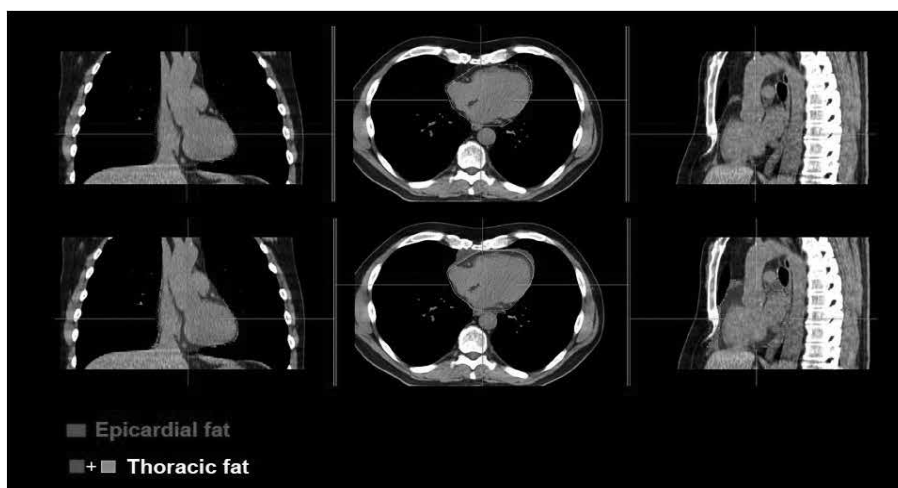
Measurement of EFV and thoracic fat From Noncontrast CT
